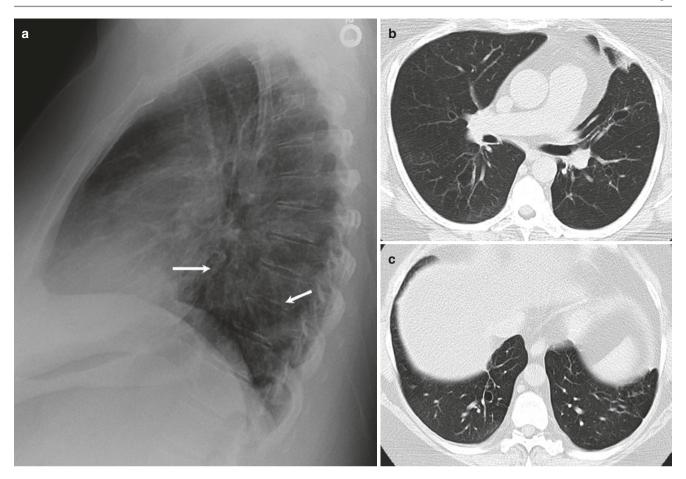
Allergic bronchopulmonary aspergillosis (ABPA) in a 37-year-old woman with long-standing steroid-dependent asthma. (a) Lateral chest radiograph shows reduced lung volume, bronchial wall
